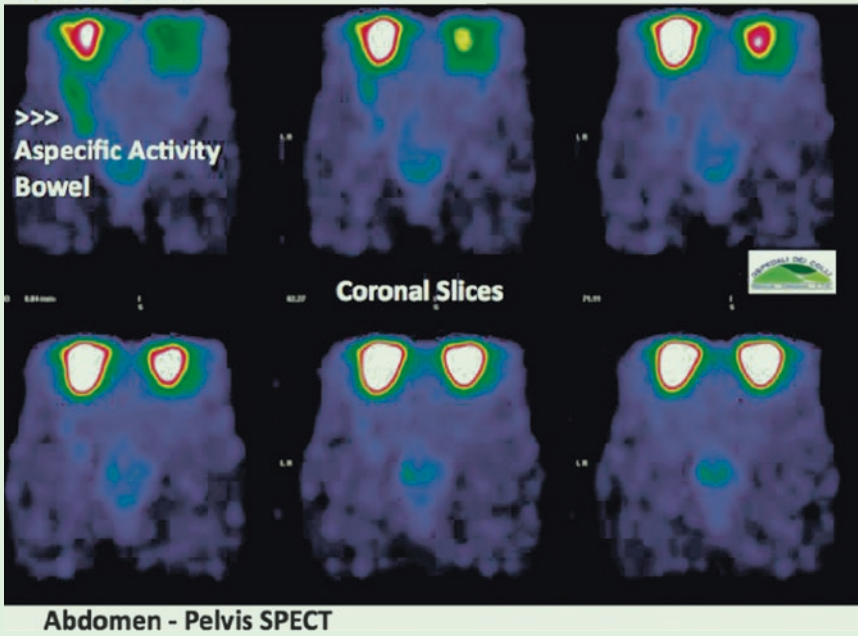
24-h ¹¹¹In-OCT AC SPECT, abdominal coronal slices
